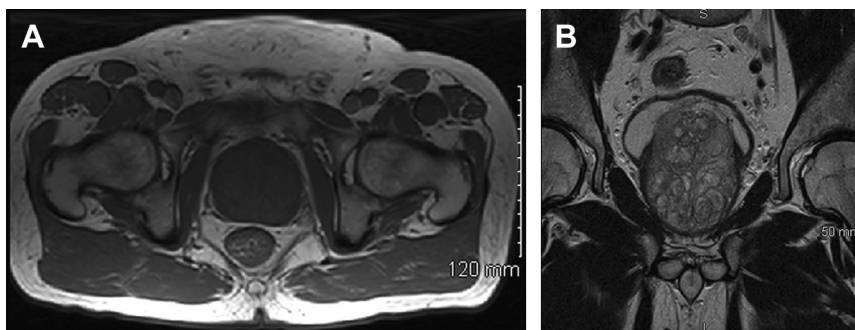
(A) Magnetic resonance imaging (MRI) axial images of large prostatic adenoma. (B) MRI coronal images demonstrating significant intravesical prostatic protrusion of prostatic adenoma.
